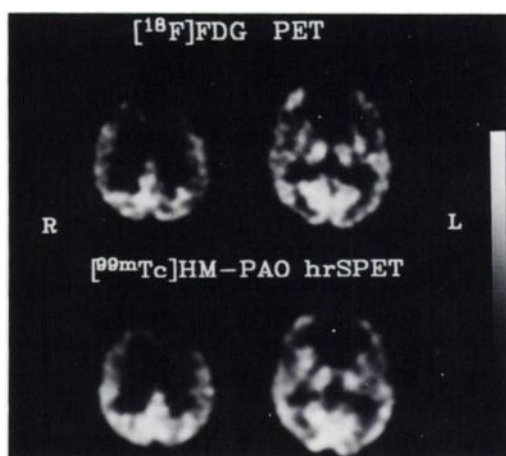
Regional glucose metabolism obtained with PET and ^{18}F FDG (top row) and perfusion obtained with high-resolution SPECT and $^{99\text{m}}\text{Tc}$ HMPAO (bottom row) in Patient 19 (Table 1). Two tomographic levels parallel to the orbito-meatal line through the mid and cranial parts of the brain are represented. Images are displayed with respect to the maximum value of each study (PET and SPECT). Both studies show hypometabolism and hypoperfusion bilaterally in the frontal cortex. PET also shows hypometabolism of the parietal cortex bilaterally.
